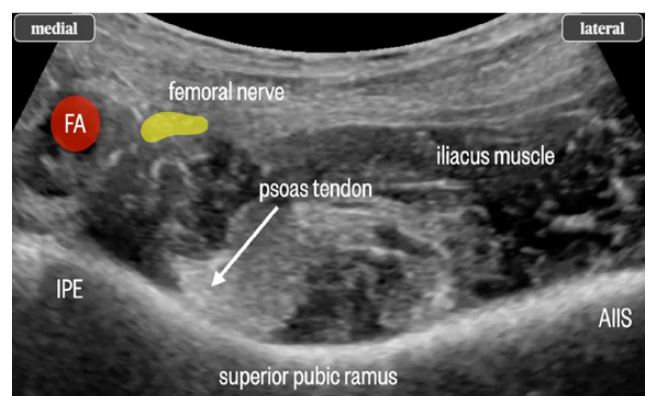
Close-up ultrasound image of anatomy relevant to PENG block. AIIS, anterior inferior iliac spine; IPE, iliopubic eminence; FA, femoral artery.
